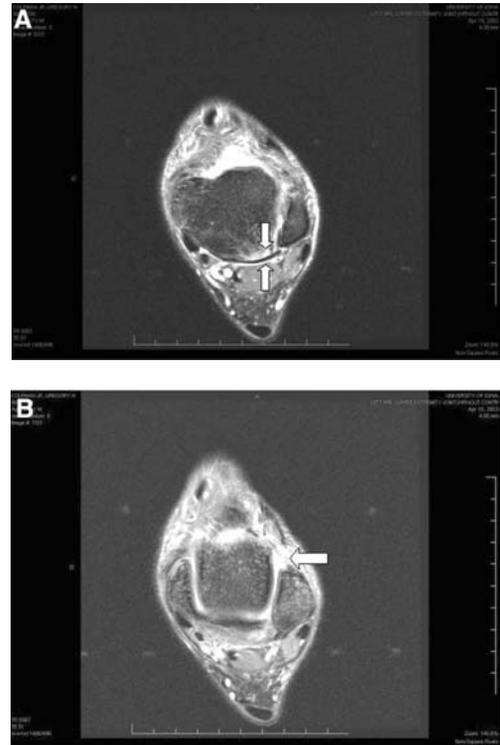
A, magnetic resonance image demonstrating a syndesmosis injury with tibial bone edema at the posterior attachment of the posterior inferior tibiofibular ligament with an intact ligament. B, the same magnetic resonance image showing a torn anterior inferior tibiofibular ligament.
